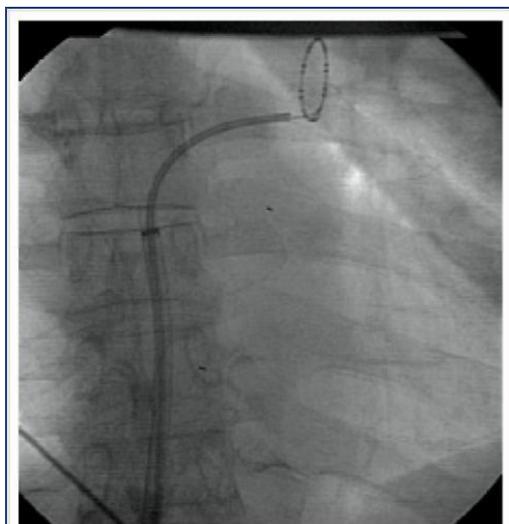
A CT image demonstrating a circular mapping catheter (Lasso) exploring potential foci around the left upper pulmonary vein orifice.
